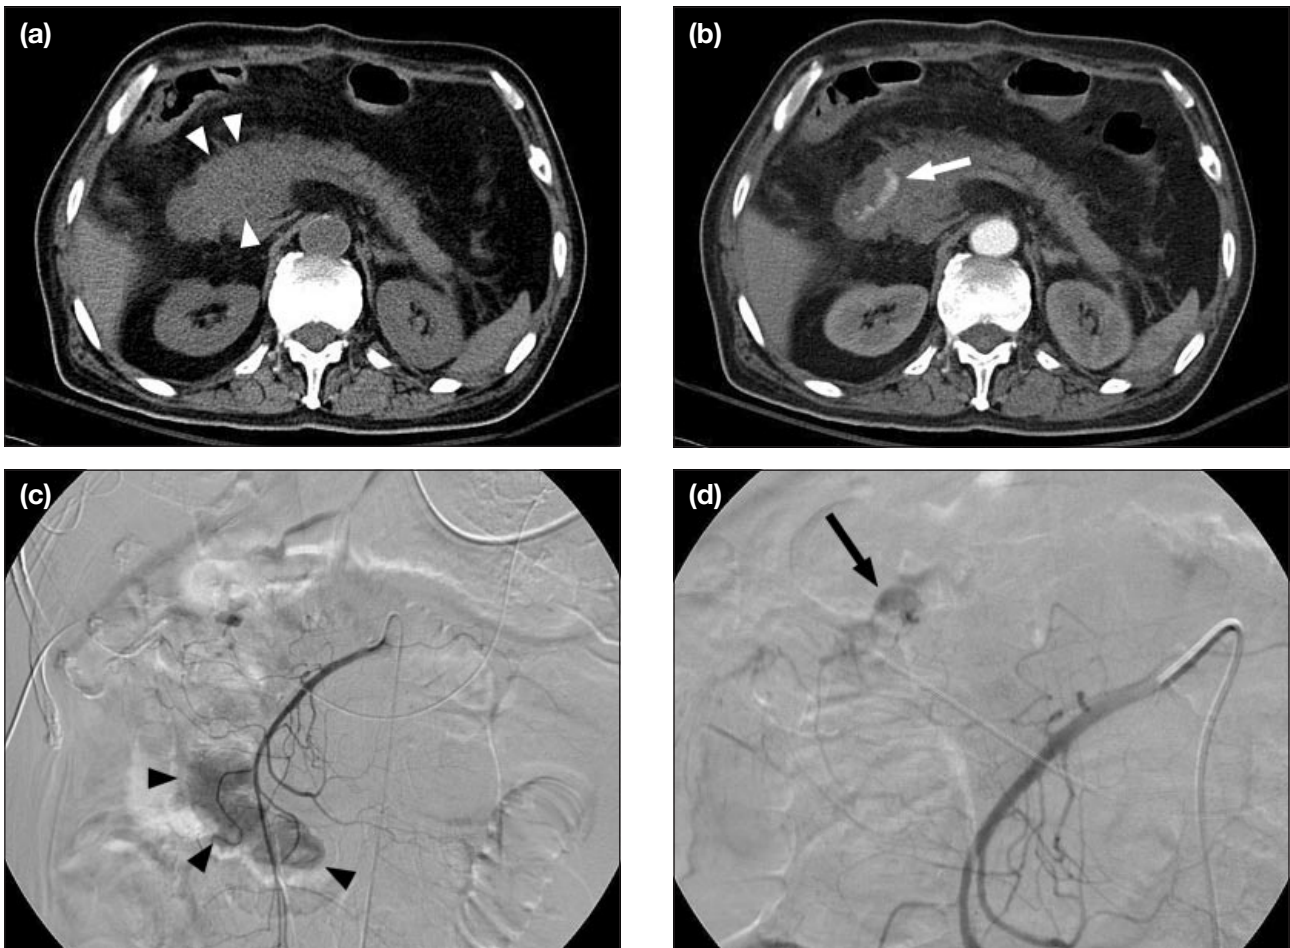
A patient presenting with haematemesis. Multi-detector computed tomography scan (without contrast) showing a haematoma in the duodenum (white arrowheads); (b) corresponding multi-detector computed tomography scan (with contrast) showing active contrast extravasation (white arrow) into the duodenal haematoma; (c) corresponding angiogram from the gastroduodenal artery showing active contrast extravasation (black arrowheads) into the duodenal lumen; and (d) corresponding superior mesenteric angiogram showing active contrast extravasation (black arrow) in the region of the duodenum.
